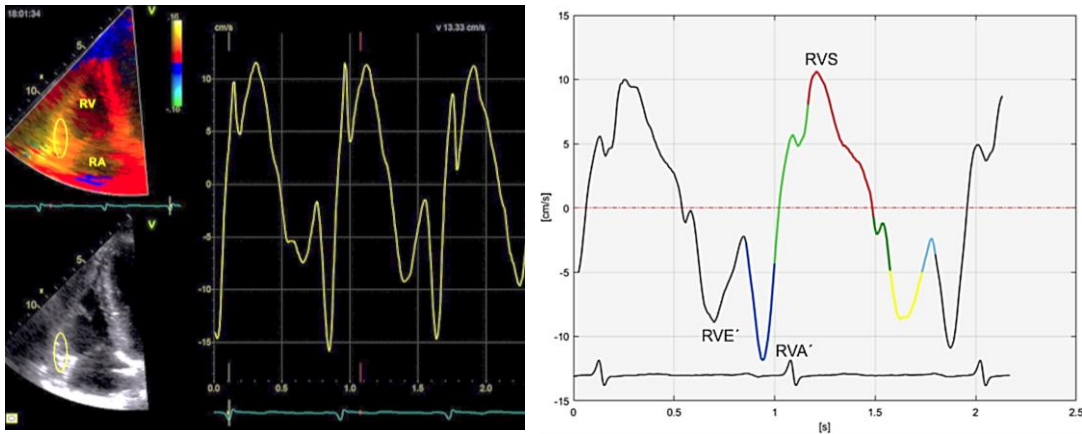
Position of ROI on color-DTI echocardiogram (left), measuring RVS by CHLab (right).
